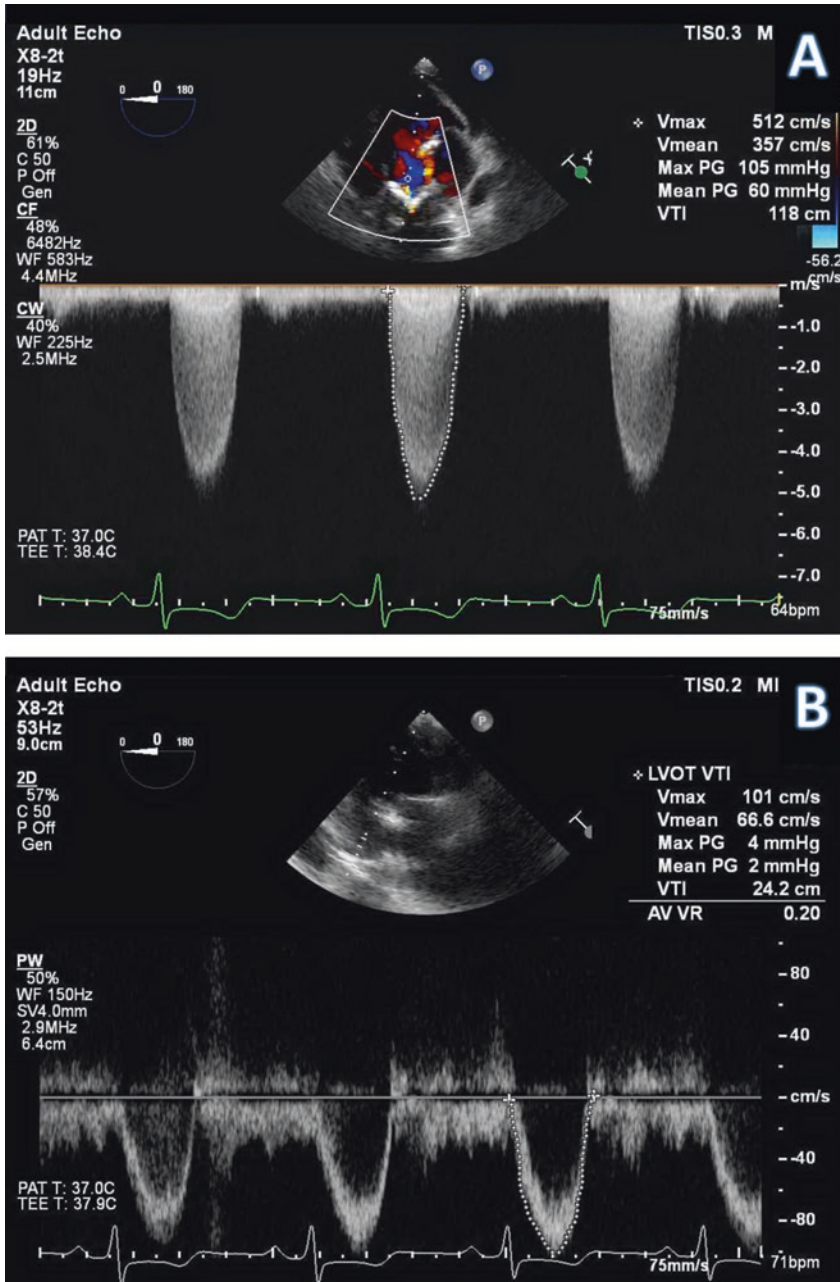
(a, b) (a) Continuous wave Doppler (CWD) through the aortic valve (AV). Note how the tracing is filled in. (b) Pulse wave Doppler (PWD) through the AV but has an “empty” tracing
